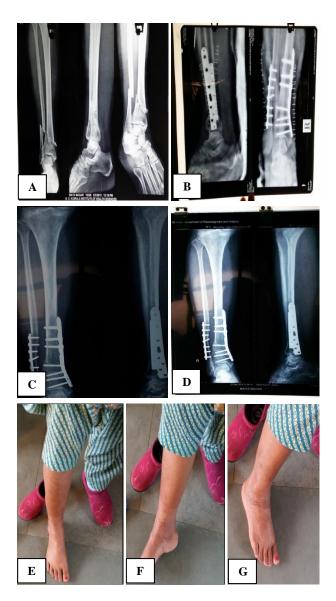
Distal tibial plating. A=X-ray at time of presentation; B=post-operative X-ray in a patient who underwent P; C=6 weeks follow up in a patient who underwent P; D=12 weeks follow up in a patient who underwent P; E-G=Assessing Range of motion (ROM) and functional status in a patient who underwent P.
